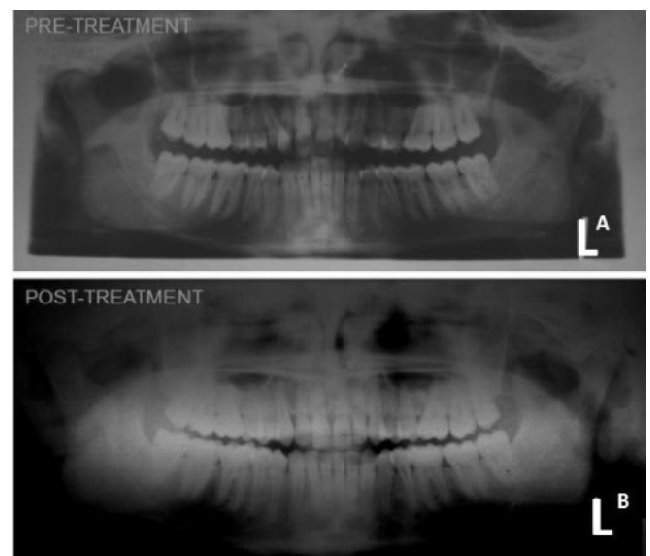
Pre-treatment (A) and post-treatment (B) Orthopantomogram (OPG)
